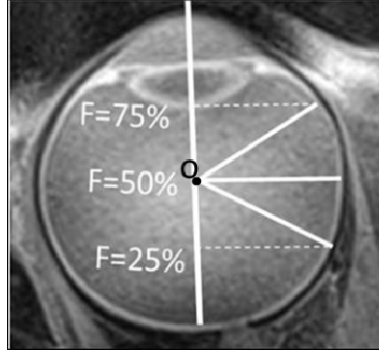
Fractions of eye (F) used to determine retinal shape estimates with MRI, the maximum being 75% and the minimum being 25%.
